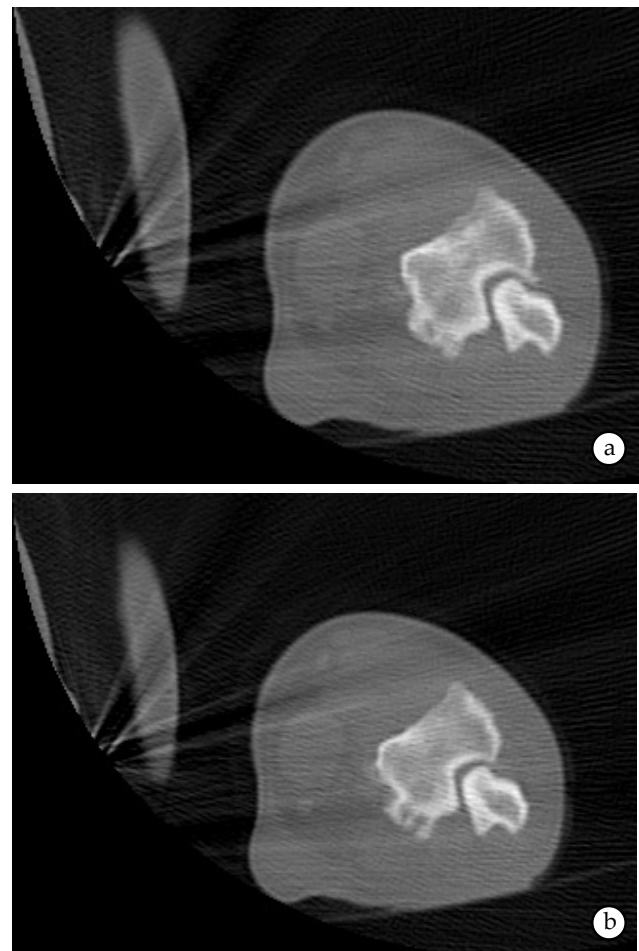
CT images of osteoarthritic elbow joint (axial view, 5 mm); showing osteophytes at humeral condyle and olecranon process of ulna.
